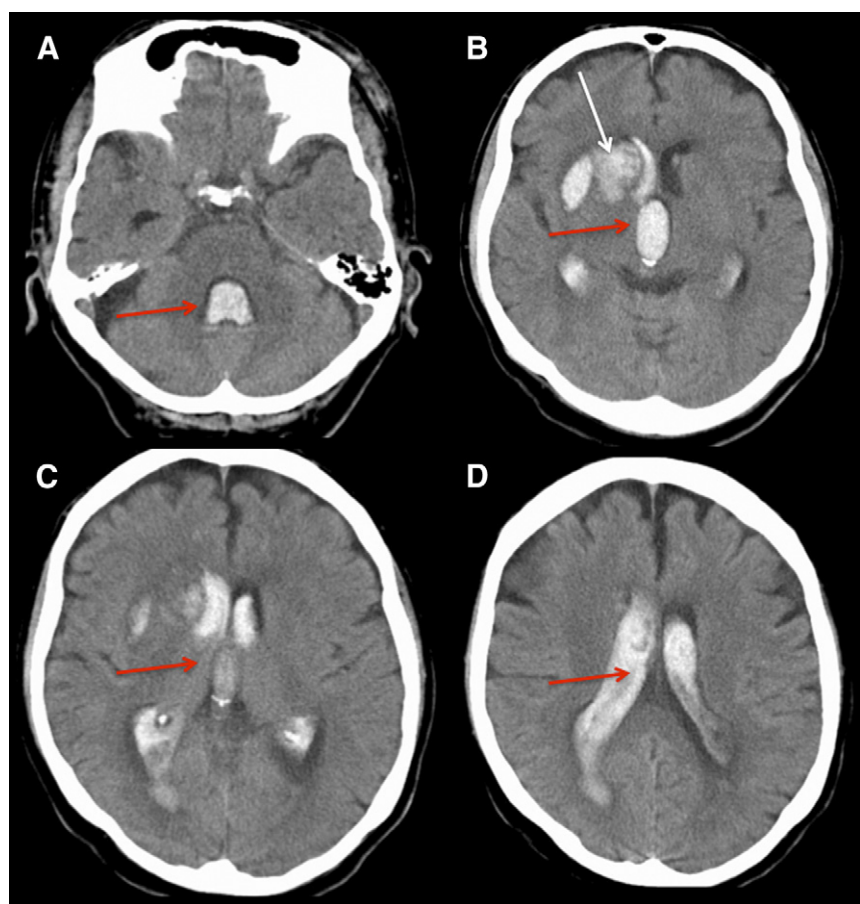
Endoscopic aspiration of intraventricular hemorrhage. Computed tomography of the head reveals a right caudate hemorrhage (white arrow, B) with severe tetraventricular flood and acute hydrocephalus (red arrows, A, C, and D).
